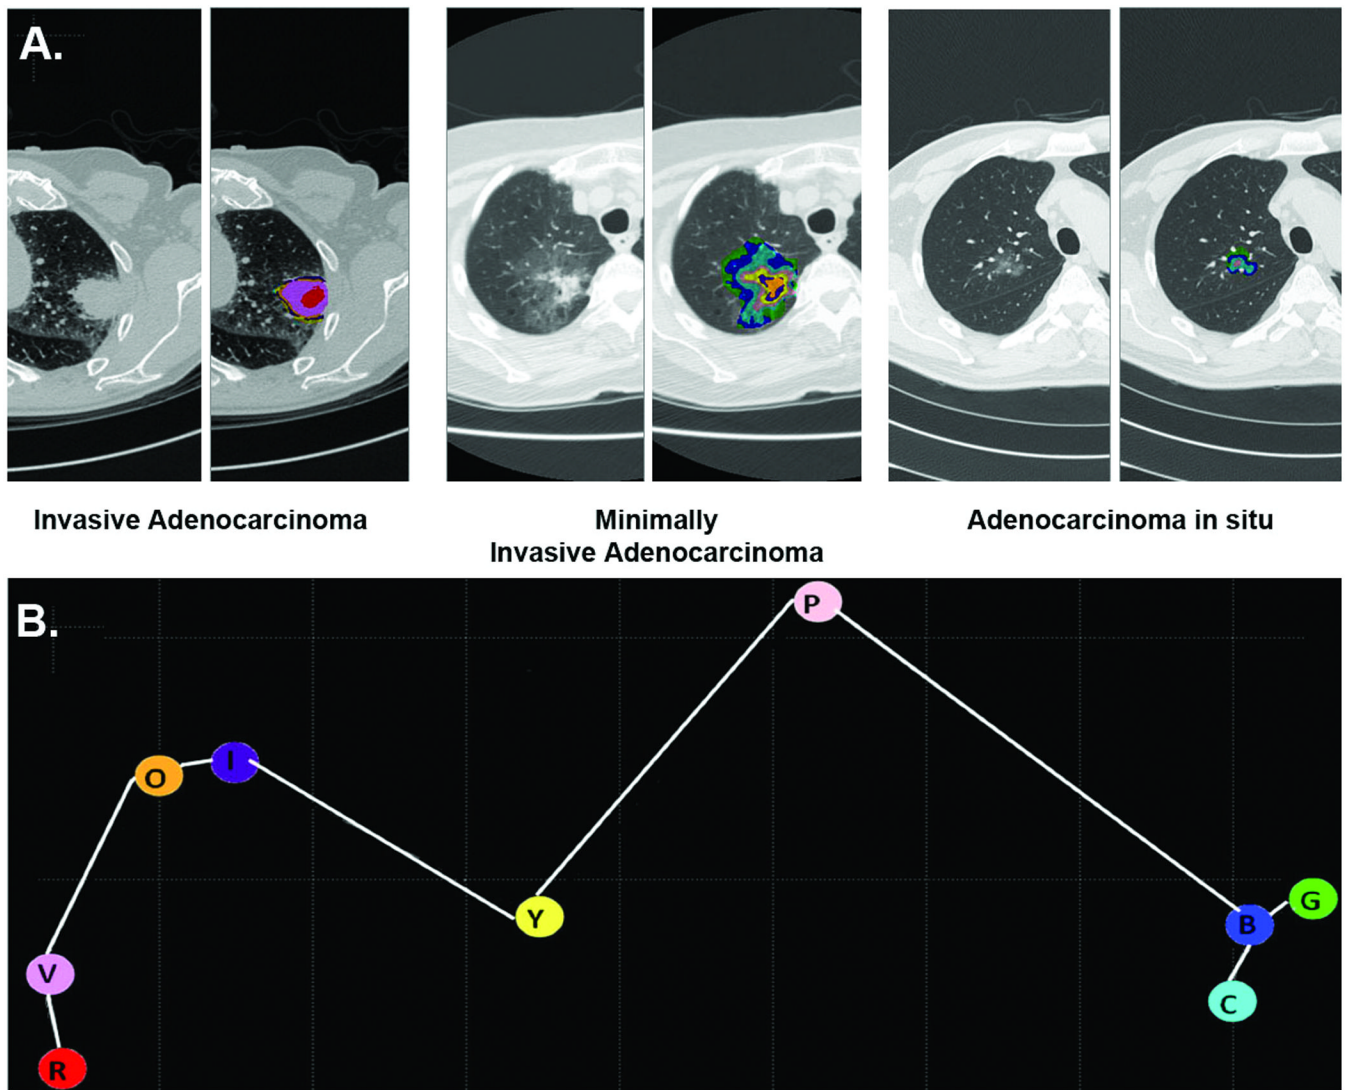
Representative signatures for invasive adenocarcinoma, minimally invasive adenocarcinoma and adenocarcinoma in situ (Panel A). Representative CT images with the superimposed distribution of the 9 adenocarcinoma exemplars are shown for IA, MIA and AIS. Panel B shows the three-dimensional distribution of the 9 adenocarcinoma exemplars using Multi-Dimensional Scaling. It demonstrates the secondary clustering of the exemplars, violet-indigo-red-orange (V-I-R-O) representing invasion, yellow-pink (Y-P) and blue-green-cyan (B-G-C) representing lepidic growth.
